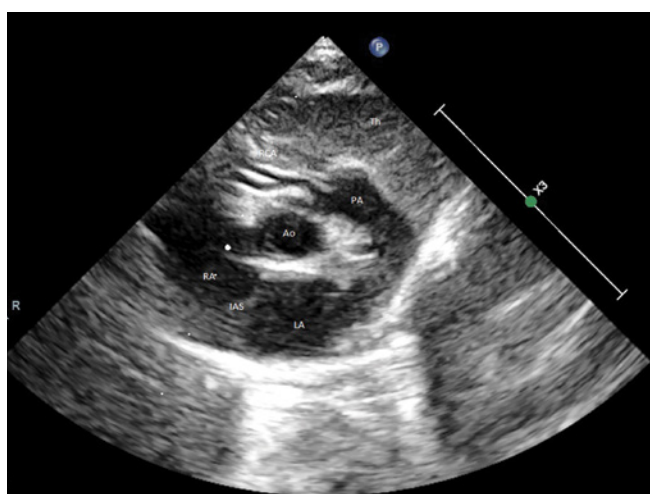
Origin of the right coronary artery from the pulmonary artery visualized in ECHO 2D, in modified cross-sectional parasternal projection. PA – pulmonary artery, Ao – cross-section of the initial segment of the ascending aorta, RCA – right coronary artery, LA – left atrium, RA – right atrium, Th – thymus, IAS – interatrial septum
